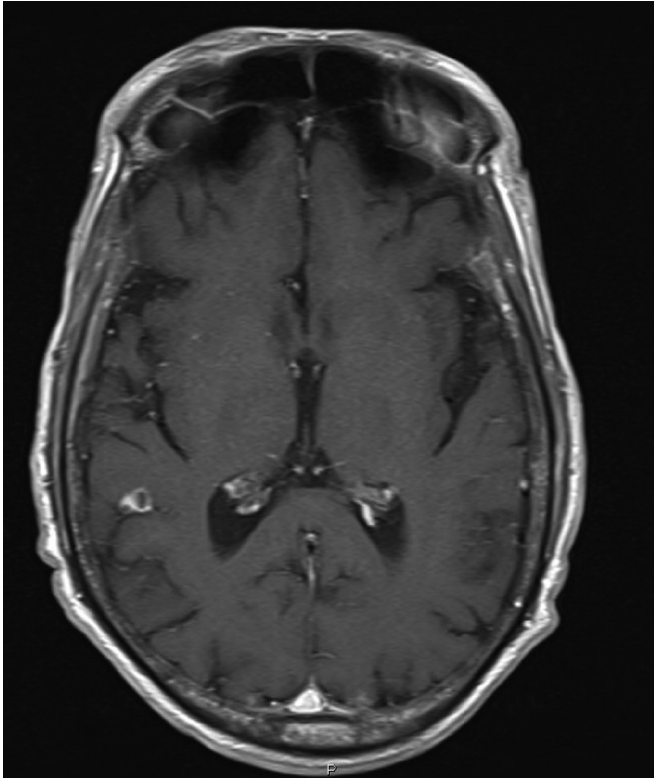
MRI T1 image with gadolinium showing a focal lesion in the right parietal lobe.
